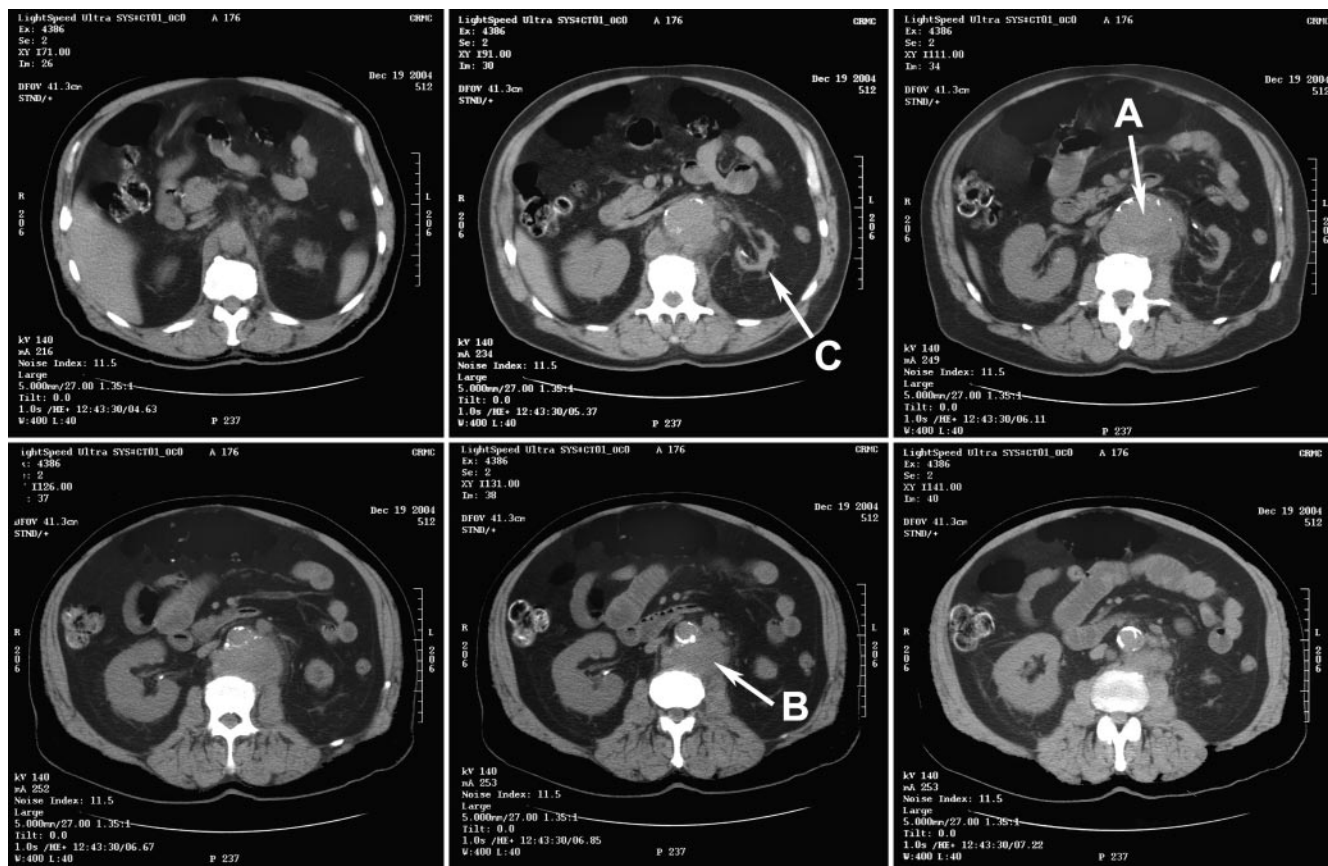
Patient's preoperative abdominal CT showing mycotic abdominal aortic aneurysm (A), peri-aortic abscess and debris (B), and atrophic left kidney (C).
